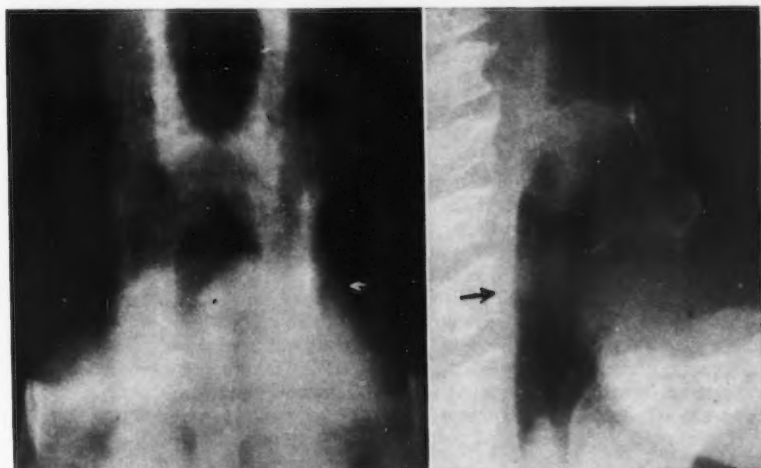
Figure 2 shows the lateral roentgenogram of larynx and antero-posterior tomogram of larynx. In the lateral roentgenogram the bulky soft-tissue mass involving the upper third of the epiglottis is well seen. In the tomogram the soft-tissue mass involving the right half of the superior portion of the epiglottis displaces the adjacent air shadow. There is slight swelling of the right false cord probably owing to edema.
